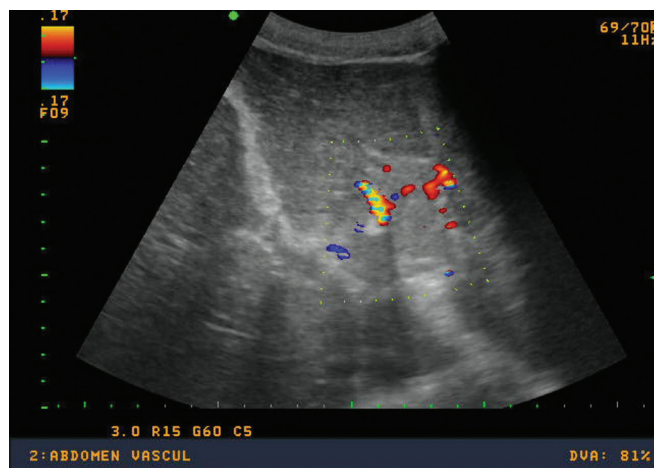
Color Doppler USG of liver showing thrombus filling the entire lumen of the portal vein with flow within the thrombus.
